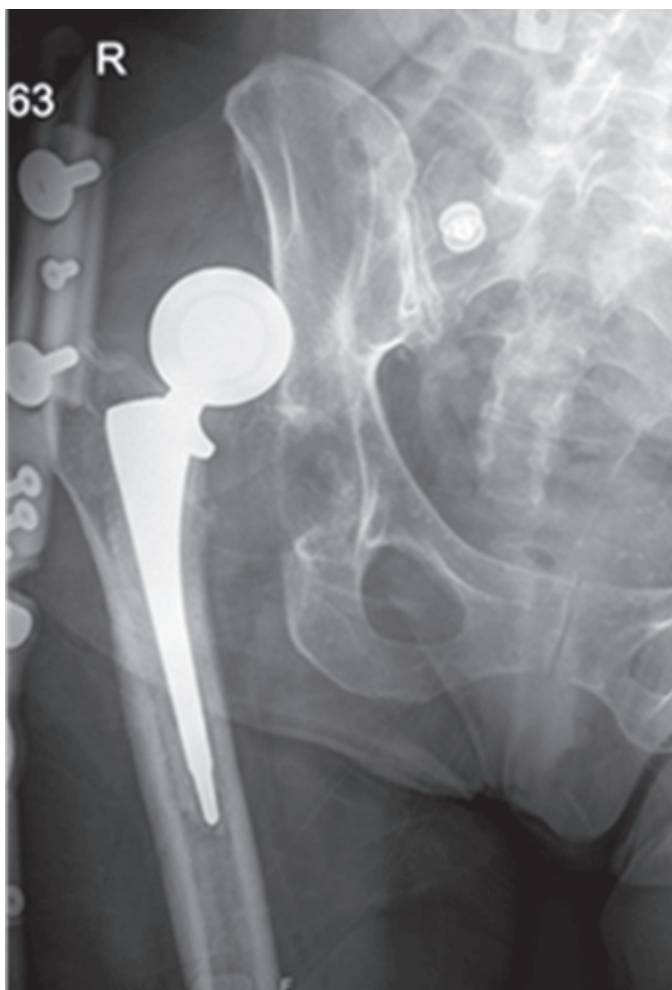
Radiograph of right dislocated hip two weeks after first clinic visit.
